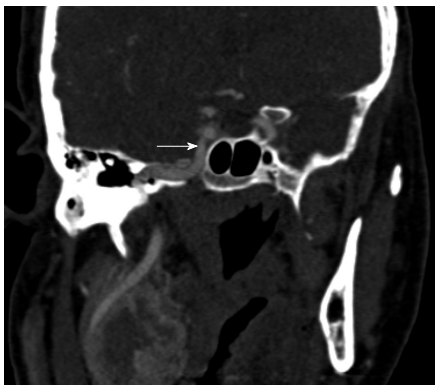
Coronal computed tomography reformat. A: The paranasal sinuses demonstrating a deviated septum to the right side (arrow); B: Mucosal thickening of the inferior turbinate on the left side (arrow); C: A pneumatized left middle turbinate (arrow); D: The uncinate process (arrow); E: The ethmoid bulla adjacent to the left orbit (arrow), note its extent to the floor of the anterior cranial fossa cranially and lamina papyracea laterally; F: A dehiscent lamina papyracea on the left side (arrow); G: An infra-orbital cell (Haller cell) (arrow); H: The posterior ethmoid cell (arrow) directly anterior to the sphenoid sinus; I: At level of sphenoid sinuses, thinning of the bony in the superolateral right sphenoid sinus adjacent to the right optic nerve (arrow head); J: The agger nasi cell (arrow) which lies inferior to the frontal recess and lateral to the middle turbinate; K: The anterior ethmoidal artery (arrow) traversing the anterior ethmoid air cells, which is susceptible to injury during functional endoscopic sinus surgery; L: A type III olfactory fossa (arrow).
